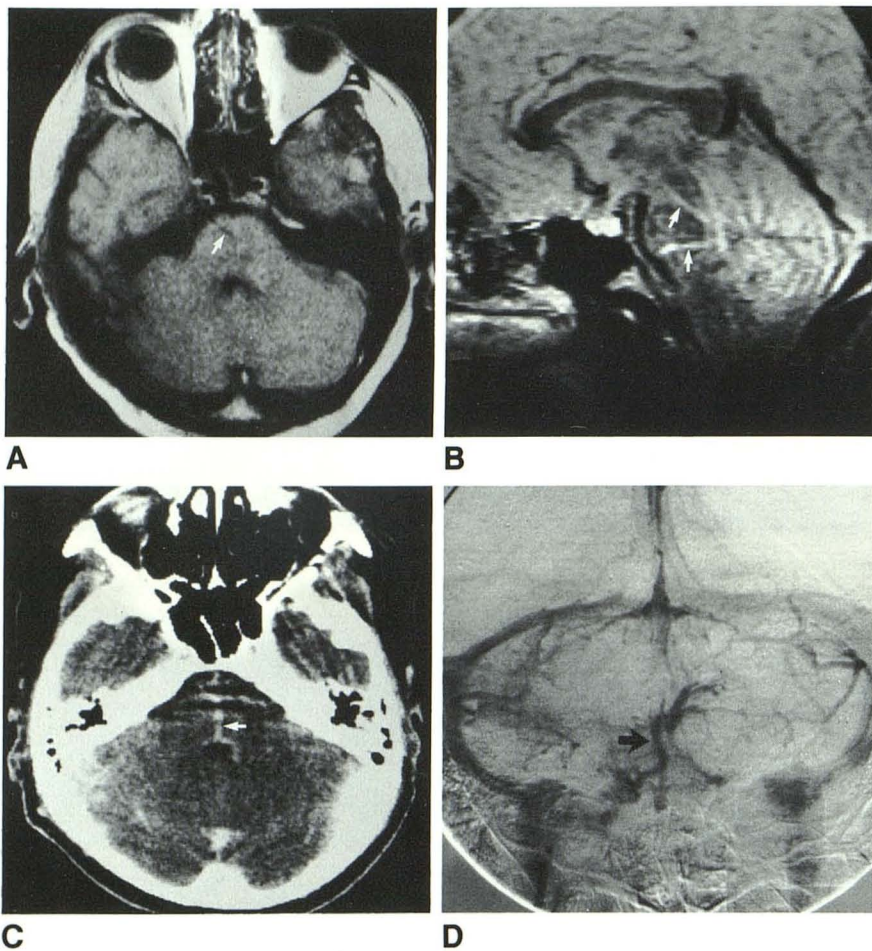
A, Axial SE 30/500 scan. Linear strand of decreased signal within pons extending to right side anteriorly (arrow). B, Sagittal SE 90/2000 scan. Multiple linear increased signal within pons and mid-brain (arrows). C, Contrast-enhanced CT scan. Abnormal vessel traversing pons (arrow). D, Venous phase of angiogram confirms abnormal veins within brainstem and cerebellum (arrow). Angiographic diagnosis: venous malformation.
